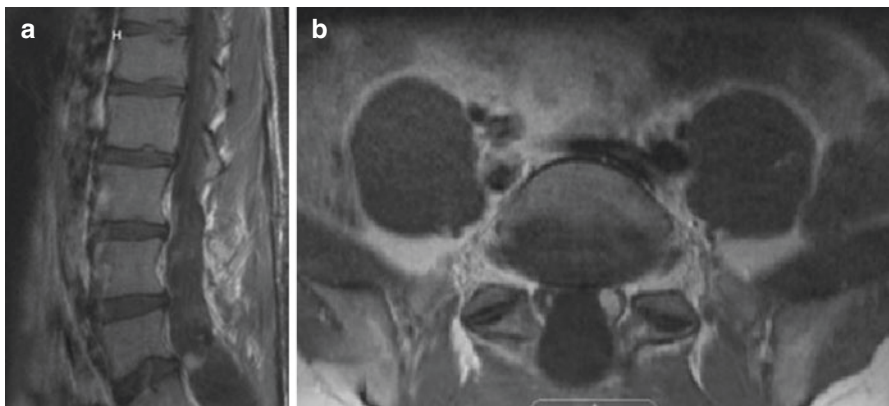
Sagittal (a) and axial (b) MRI showing intradural growth of small left L5–S1 component
